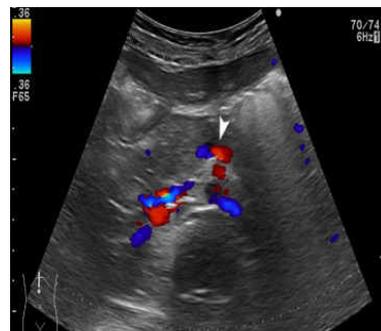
Colour Doppler imaging in a boy with mesenteroaxial gastric volvulus. Transverse post-operative colour Doppler imaging showing the restoration of mesenteric vessels to their normal position and relation.
